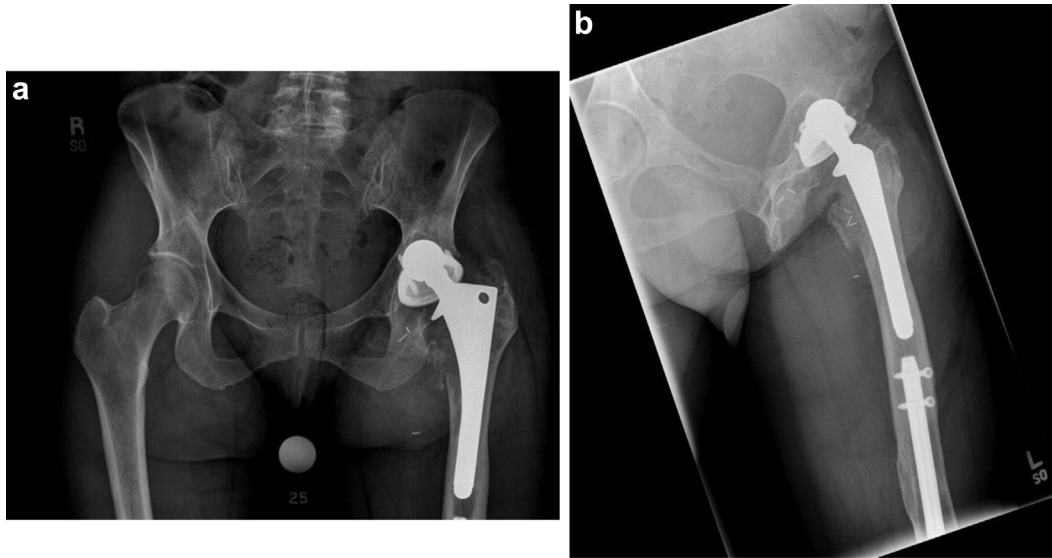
Anteroposterior (a) and frog-leg lateral (b) radiographs of left total hip arthroplasty with complete wear of the polyethylene liner and the acetabular socket resulting in femoral head protrusion into the pelvis (3-month interval from Fig. 3)
